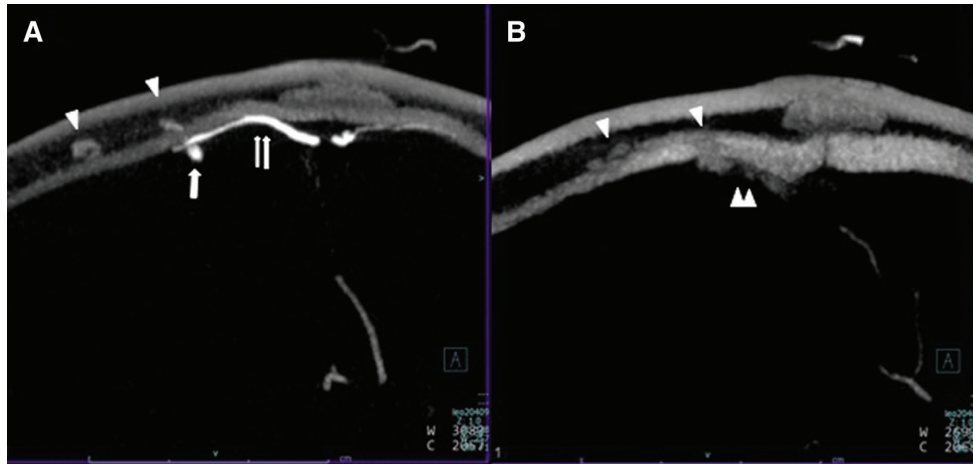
Cone-beam CT shows (A) an AVF fed by a frontoparietal branch of the left MMA (double arrow). Its shunting point had an aneurysmal sac (arrow) directing to a subdural space, and drained into a diploic vein (arrowheads). (B) An AVFs drained into a diploic vein (arrowheads) and then drained into the SSS via the venous lacuna (double arrowhead). AVF: arteriovenous fistula; MMA: middle meningeal artery; SSS: superior sagittal sinus
